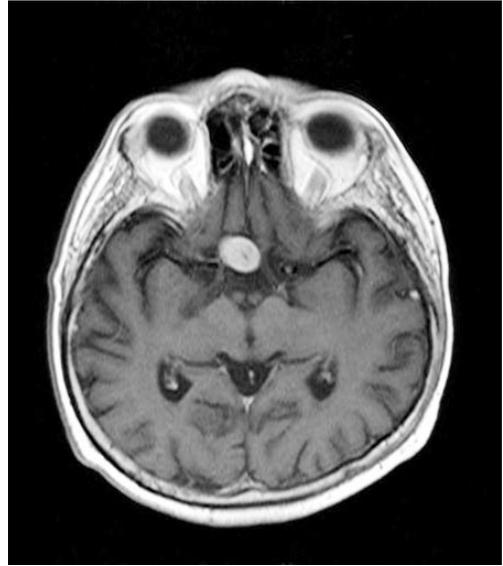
Tumour mass in suprasellar region presented by magnetic resonance imaging (MRI), axial image.
